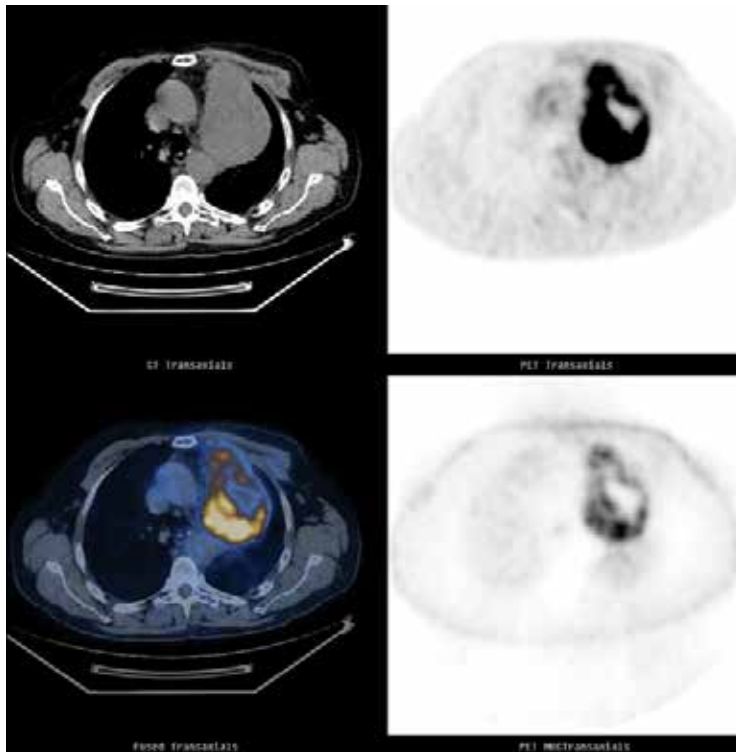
Fused PET-CT image of a lung cancer.
